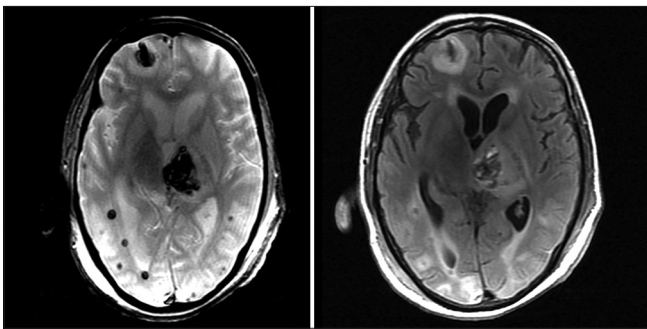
GRE and FLAIR images of the brain taken at the level of basal ganglia shows multiple cerebral hemorrhages
